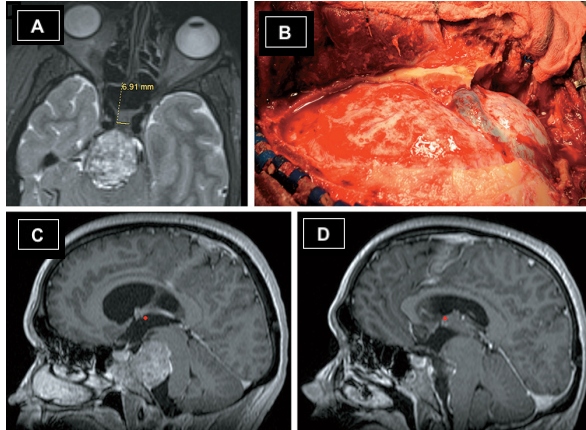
A) Preoperative axial MR T2-weighted image showing a clivus chordoma arising in the midline and displacing posteriorly the brainstem. The sellar inter-carotid distance is barely 7 mm. Due to the short ICA-ICA distance we decided to perform a one-stage combined subtemporal trans tentorial and retrosigmoid approach. B) Intraoperative view of the craniotomy with full-exposition of sovra- and infra-tentorial regions and transverse-sigmoid sinus junction. C) Preoperative sagittal MR T1-weighted image with gadolinium showing the significant chordoma extension rostral to the retrosellar and inter-peduncular fossa. D) Postoperative sagittal MR T1-weighted image with gadolinium showing gross total tumor removal [adapted from La Corte et al., 2018].
